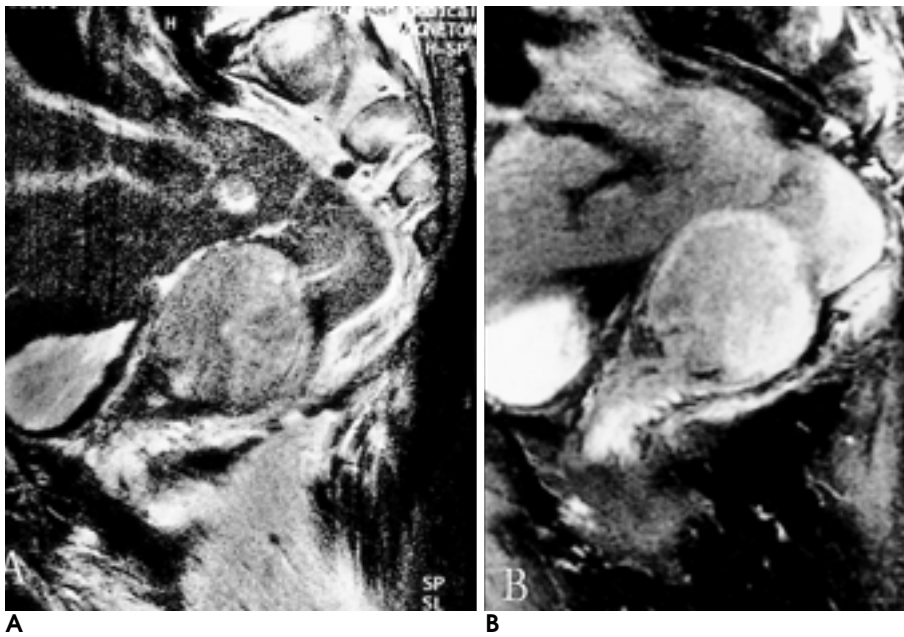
Cervical carcinoma involving endocervix and exocervix shows invasion of full-thickness uterine corpus on sagittal T2-weighted image(A) and fat-suppressed Gd-enhanced T1-weighted image(B).
